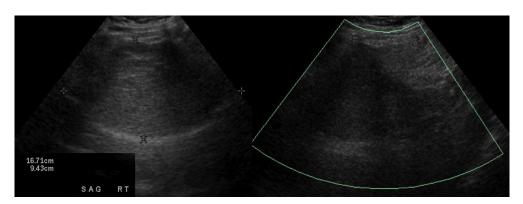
Grayscale and color Doppler ultrasound demonstrates a heterogeneous soft tissue mass without significant vascularity, overall nonspecific in appearance.
